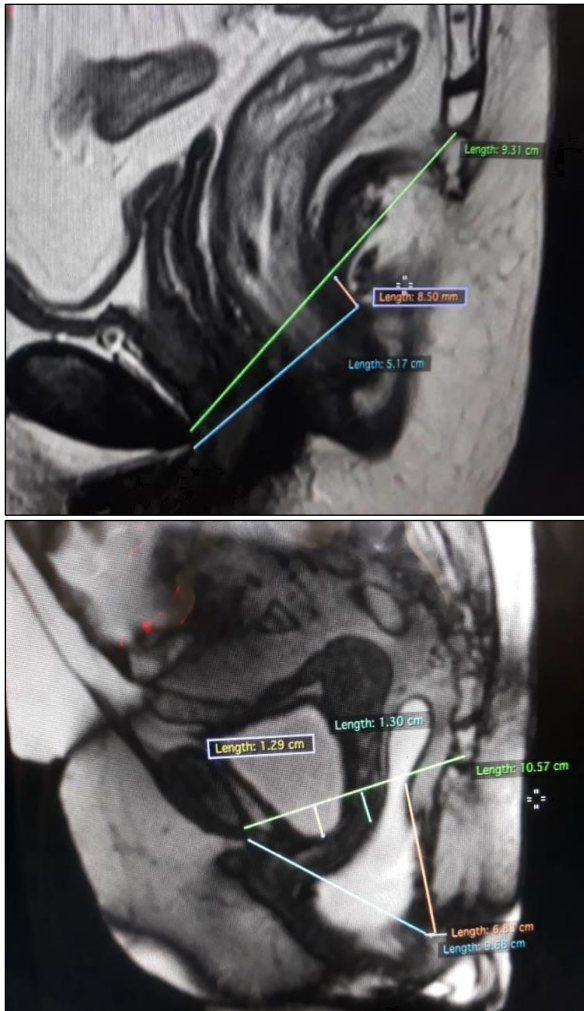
Sagittal MR images taking during resting and defecating phase showing transperineal descent with mild (<3 cms) prolapse of anterior and middle compartment, while as there is severe (>6 cms) rectal prolapse.
